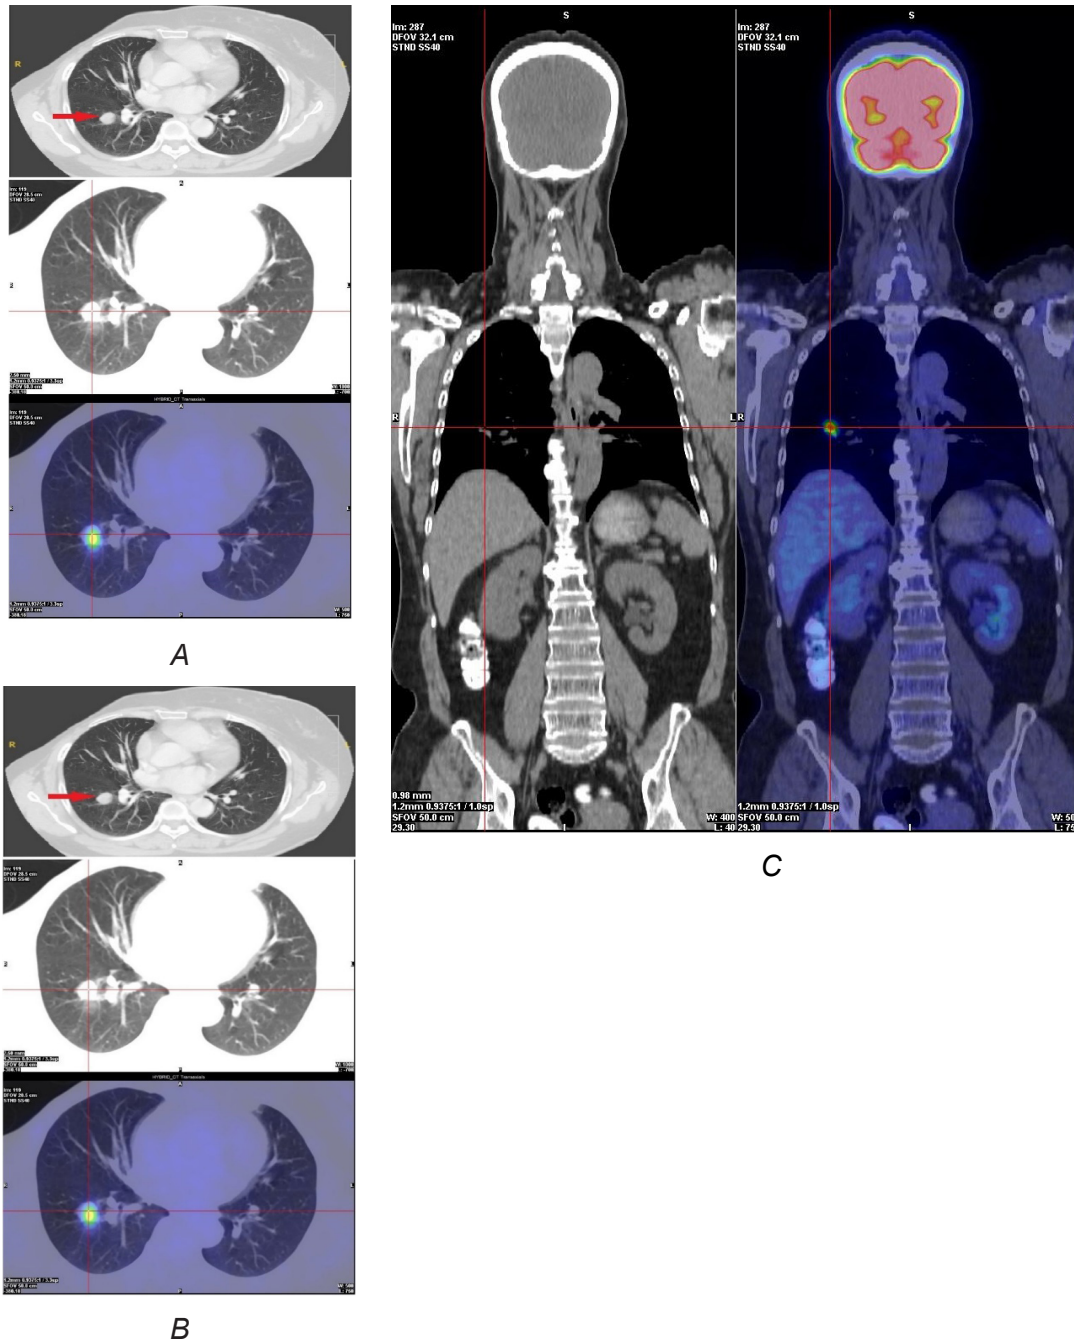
CT imaging revealed a solitary pulmonary nodule in the left lung (arrow) (Figure A). Figures B - C: FDG-PET/CT imaging demonstrated increased FDG uptake at the lesion site, with an SUVmax of 17.2, raising suspicion of metastatic disease
